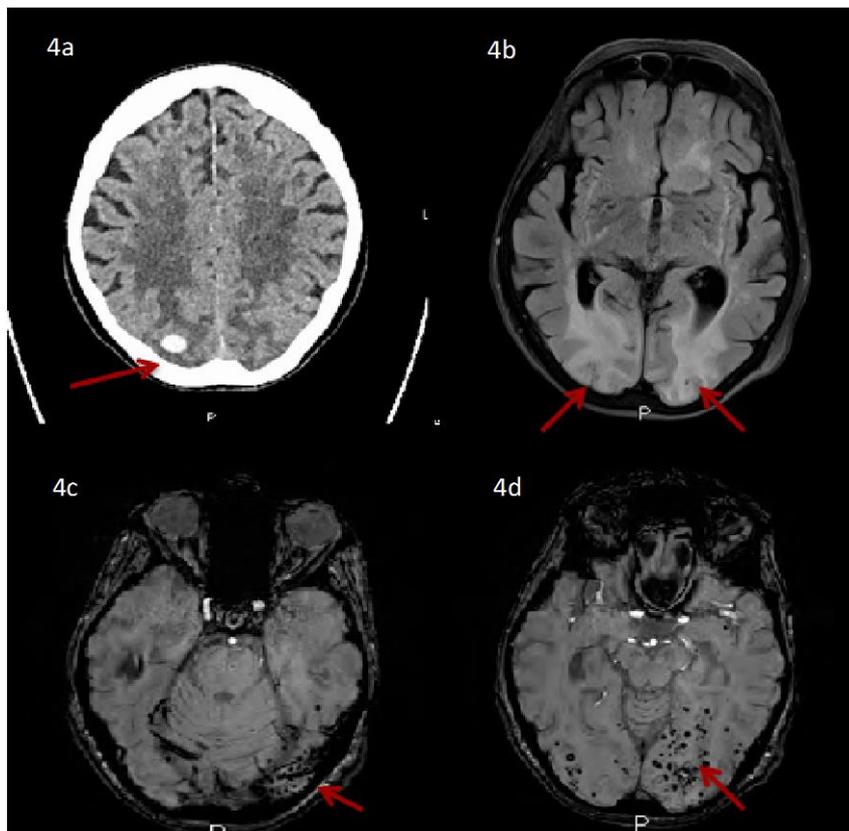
Non-contrast axial CT brain showing rounded hyperintensity consistent with acute intraparenchymal haemorrhage in the right occipital lobe .
